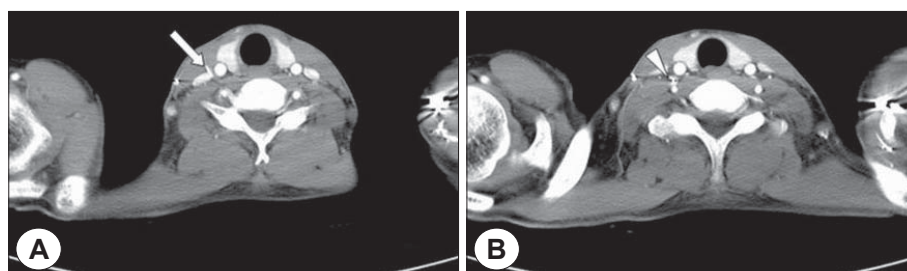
Neck CT shows that catheter of TIVAD passes between right internal jugular vein and right common carotid artery(arrow, A) and enter into small vessel, probably a vertebral vein(arrow head, B).
